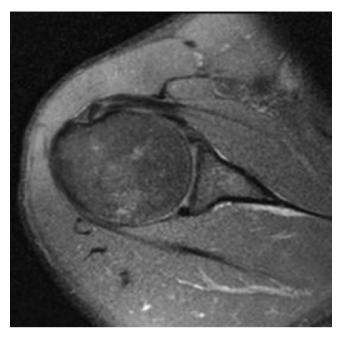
Magnetic resonance imaging revealed a signal change over the subscapularis tendon. The coracohumeral distance was narrow and measured 6 mm on axial imaging.
